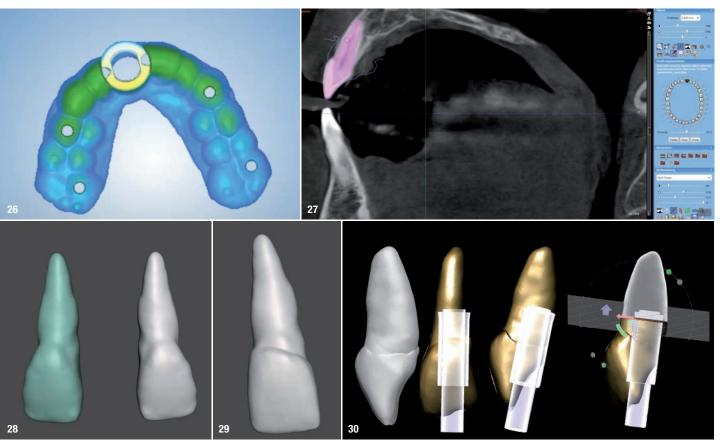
Planmeca Romexis surgical guide module. Fig. 27: Tooth segmentation feature in Planmeca Romexis. Fig. 28: Segmented tooth and root mirrored and then overlaid in Meshmixer. Fig. 29: Combined CBCT segmented tooth and digital wax-up. Fig. 30: Sectioned tooth at the margin of the abutment.
